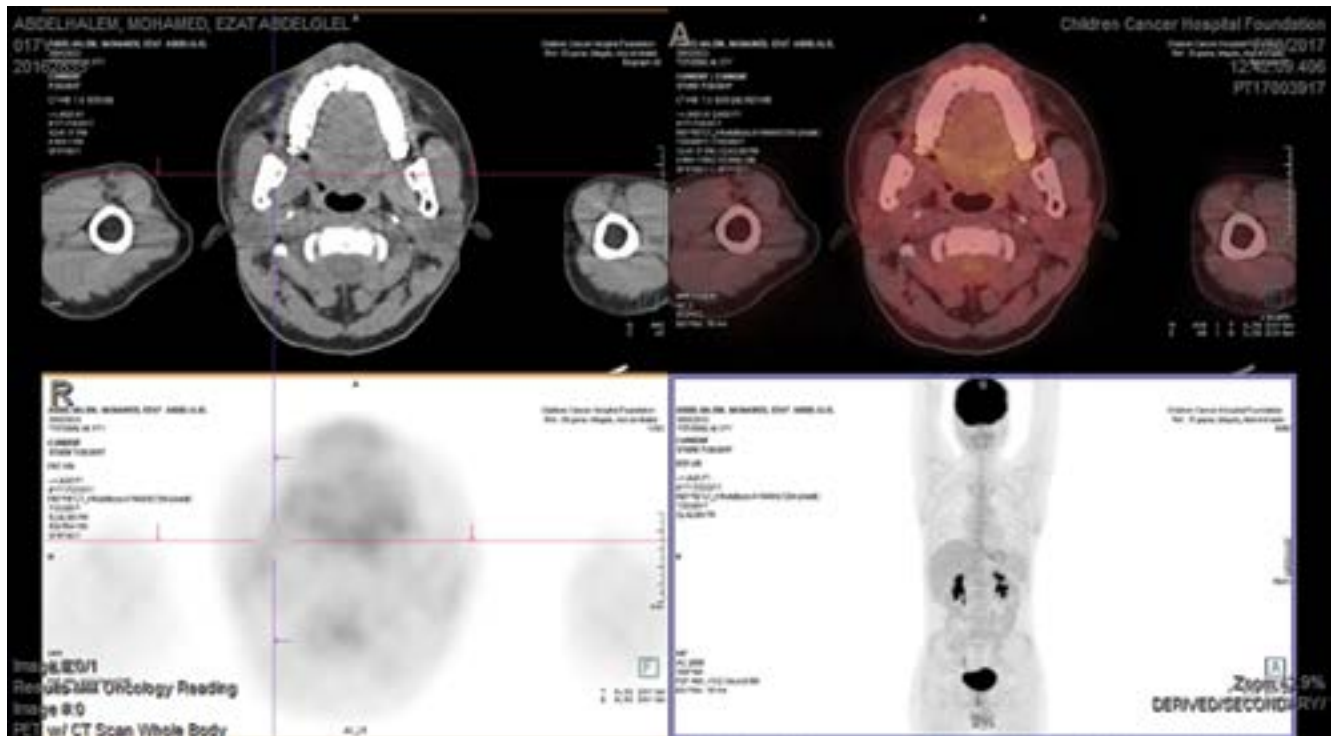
Axial and MIP images of PET/CT and fused ^{18}F -FDG-PET/CT images of the mentioned patient at W18 showing complete metabolic remission of the involved mandibular lesion
